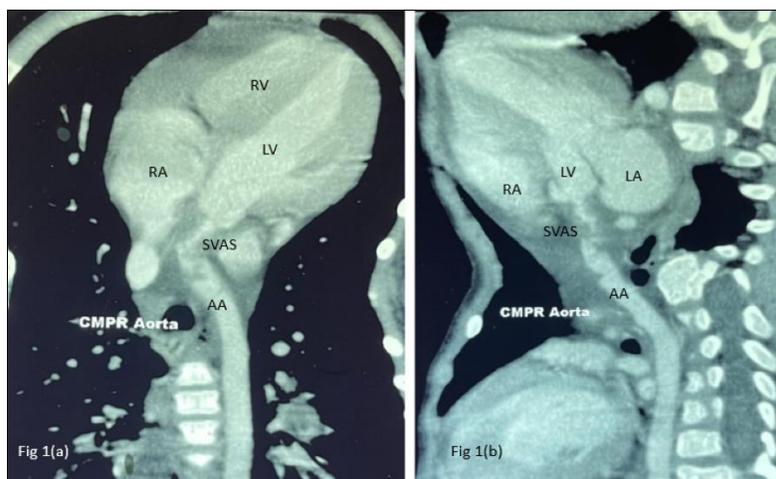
Computerized tomography angiogram (CTA) shows long segment SVAS present with thick wall, intraluminal thrombus and 4 mm patent lumen
